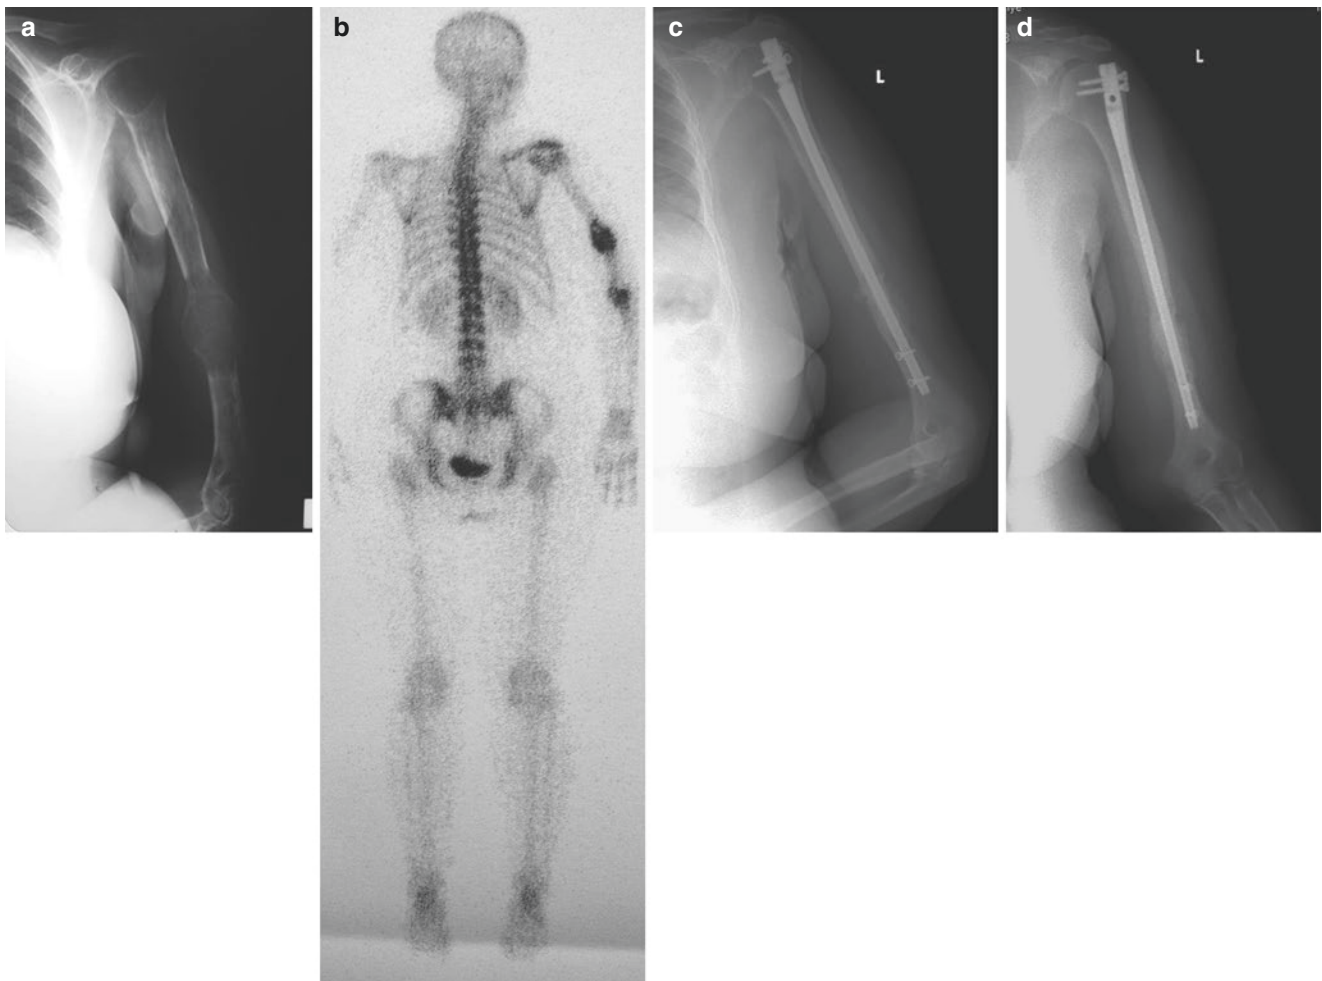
A 59-year-old woman with metastatic breast cancer. (a) AP radiograph reveals lytic lesion on the shaft of the left humerus (impending fracture). (b) A bone scan with technetium 99 reveals increased
